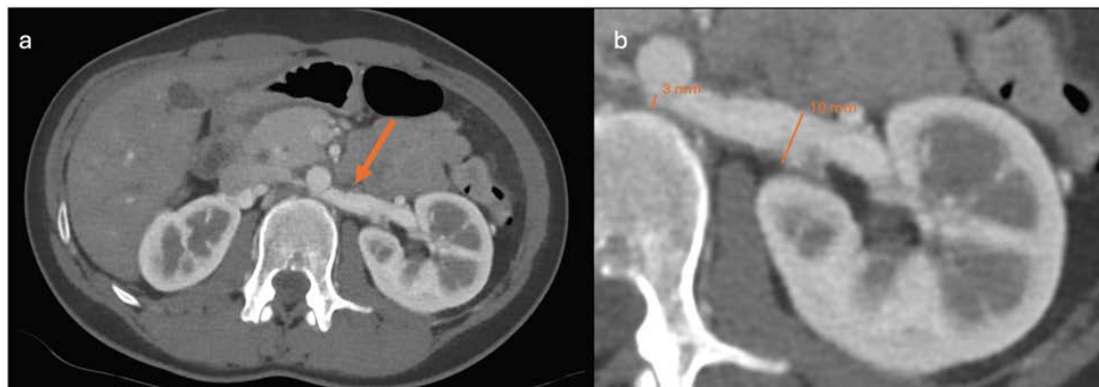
Retro-aortic left renal vein: 31-year-old female with a retroaortic course of the left renal vein joining the inferior vena cava in the normal position (Type I). *Findings:* Axial contrast-enhanced CT in the portal venous phase shows a retroaortic left renal vein (orange arrows, *image a*, magnified in *image b*) compressed between the aorta and the vertebral body (anteroposterior diameter: 10 vs 3 mm, compression ratio of 1 : 3.3), consistent with posterior nutcracker syndrome. *Technique:* Axial CT, 150 mAs, 80 kV, 1.25 mm slice thickness, portal venous phase after intravenous injection of 80 ml of iodinated contrast agent (Iohexol 300 mg I/mL).
